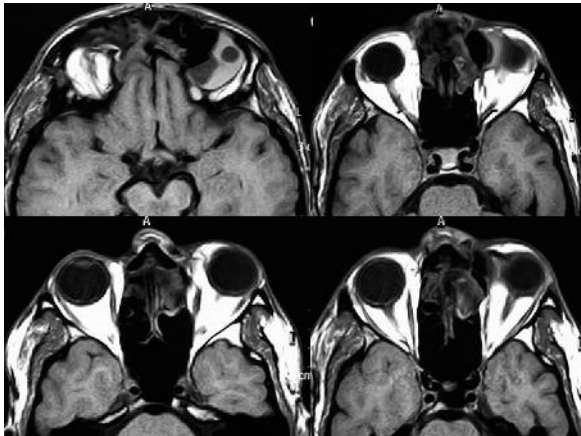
T1 weighted axial MRI scans showing a huge orbito-ethmoidal disomogeneous lesion on the left side.
